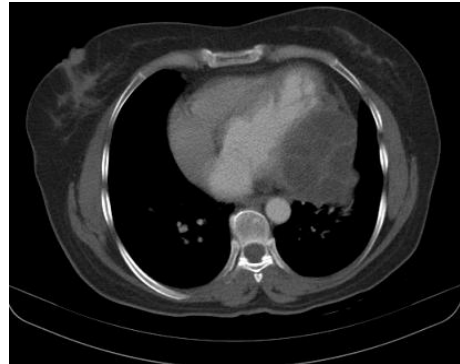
Chest CT scan demonstrates hypodense and well-defined multilocular cystic mass lesion located in the pericardium.
